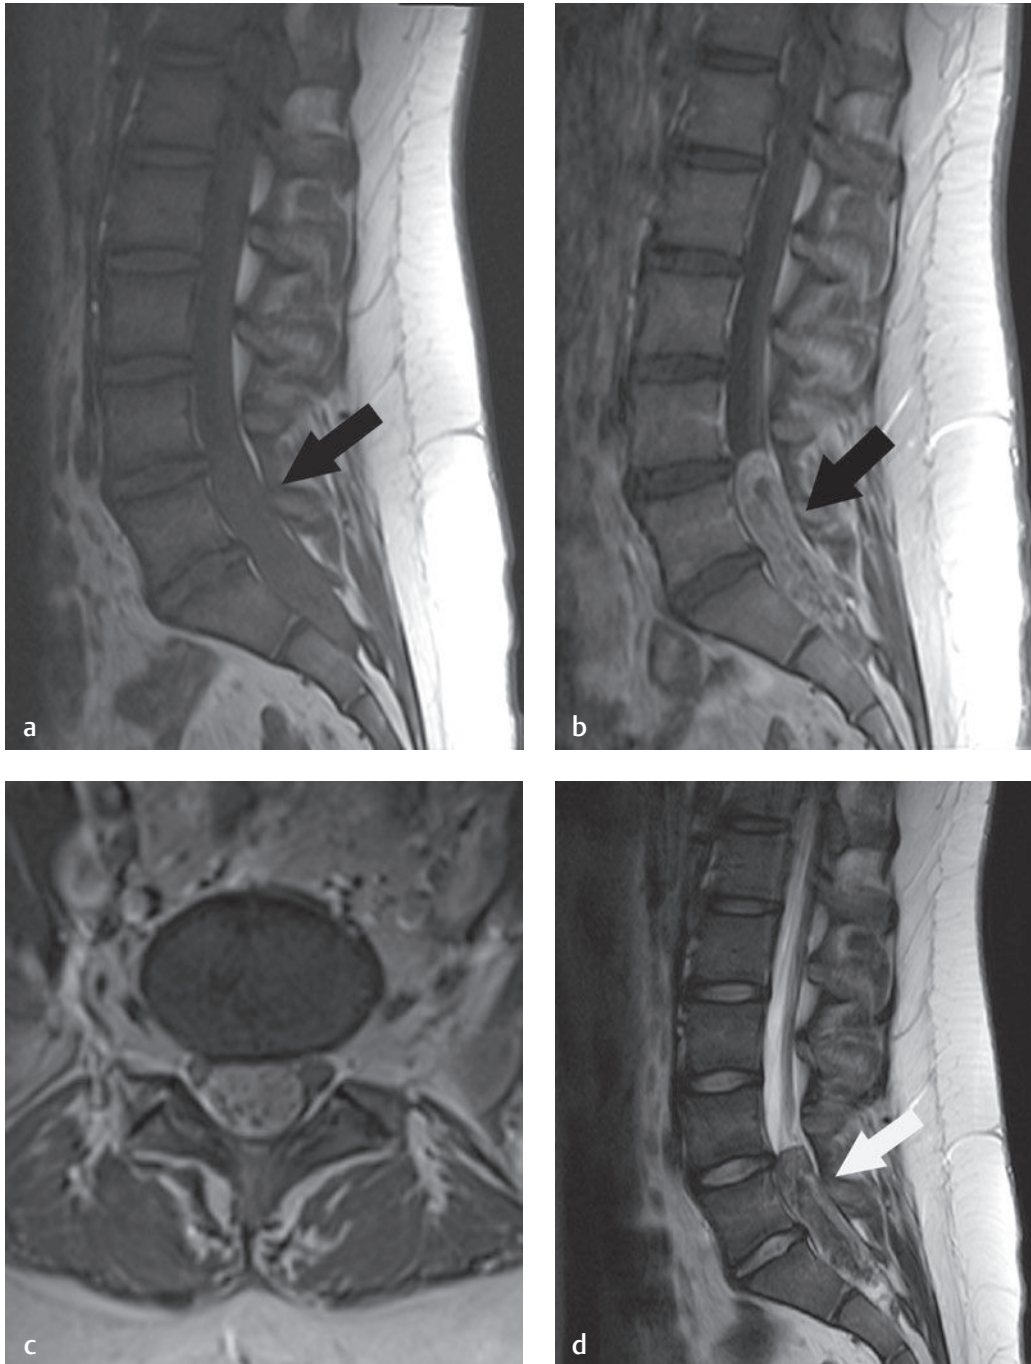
Myxopapillary ependymoma of the lumbar region. (a) A sagittal T1-weighted precontrast image shows a hypointense lesion (*arrow*). (b) Sagittal and (c) axial T1-weighted postcontrast images reveal robust enhancement of the lesion (*arrow* on b). (d) A sagittal T2-weighted image shows the lesion (*arrow*) is heterogeneously hypointense. Although derived from the filum, ependymomas in this segment of the spine reside in the intradural–extramedullary compartment.
